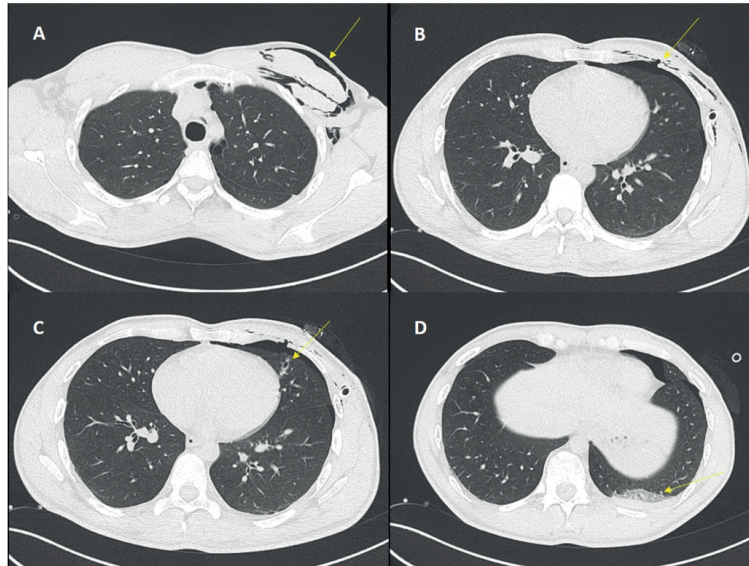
Thoracic computed tomography image of a 29-year-old male patient admitted for stab injury. A) subcutaneous emphysema due to parenchymal laceration, B) defect in the thoracic wall due to stab injury, C) parenchymal laceration, D) pulmonary contusion and hemothorax in the posterobasal region.
